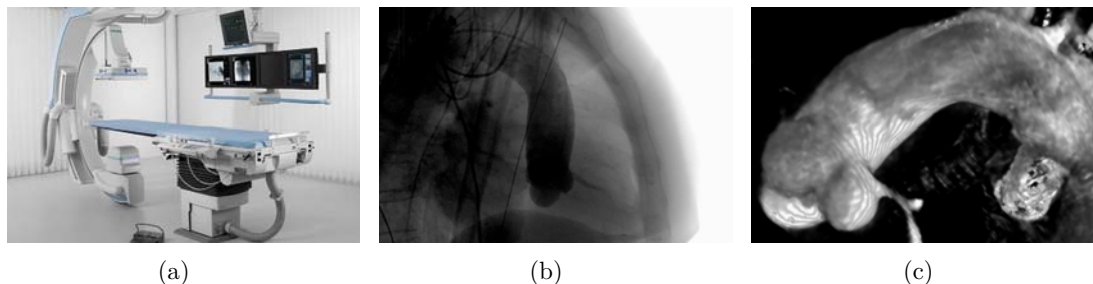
(a) C-arm X-ray - Artis zee Ceiling-mounted system, Siemens Healthcare, Forchheim, Germany. (b) Fluoroscopic image of the heart with contrast concentrated in the aorta. (c) Three-dimensional DynaCT reconstruction of the aorta.
